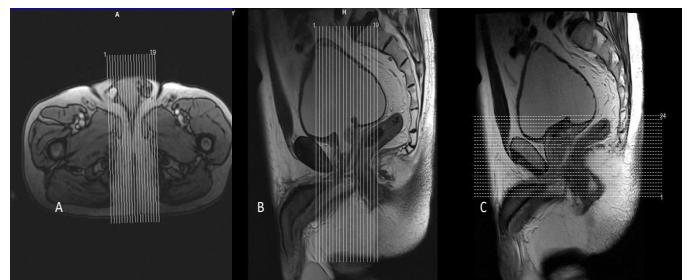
Shows the slice prescription for MRI prostate.
